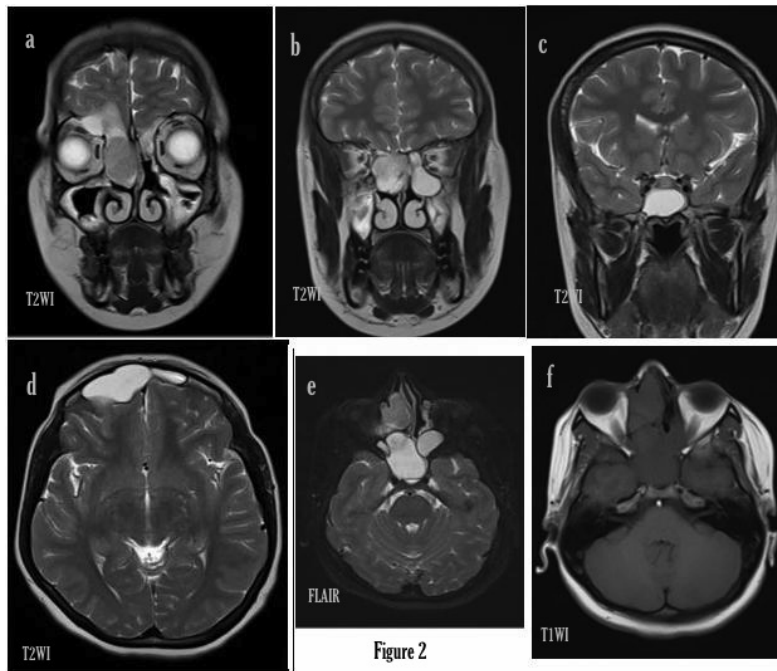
(a) Magnetic resonance imaging shows a polyp in right anterior ethmoid sinus and nasal cavity (b) Homogenous hyperintense lesion seen in bilateral ethmoid sinuses (c) Sphenoid sinus (d) Right frontal sinuses with intracranial extension (e) intraorbital extension (f) T1WI MRI images show hypointense lesion in sphenoid and ethmoid sinuses.
